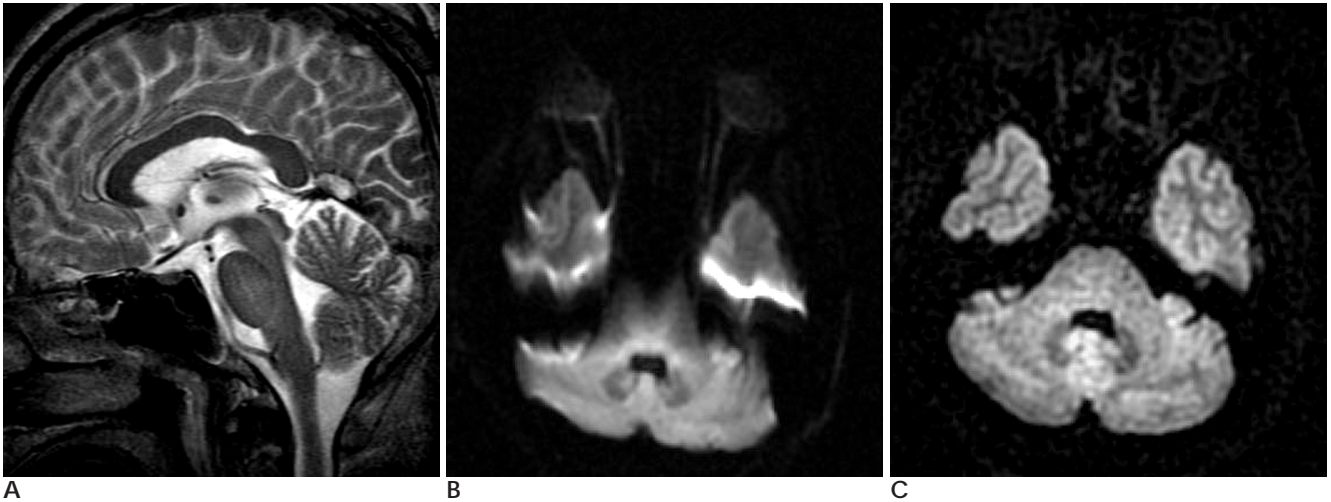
Midsagittal T2-weighted image (A) shows type-2 pneumatic sphenoid sinus. Echo planar imaging diffusion weighted image (B) shows severe anatomical distortion of pons due to magnetic susceptibility artifact, but fast spin-echo periodically rotated overlapping parallel lines with enhanced reconstruction (PROPELLER) image clearly cancels the artifact.
